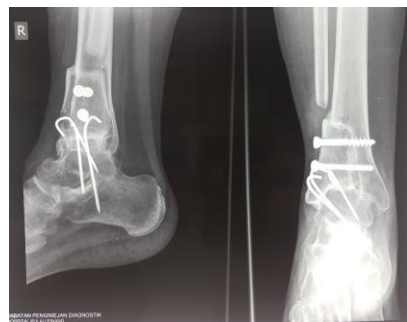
Post op 1 year x-ray shows bone union
